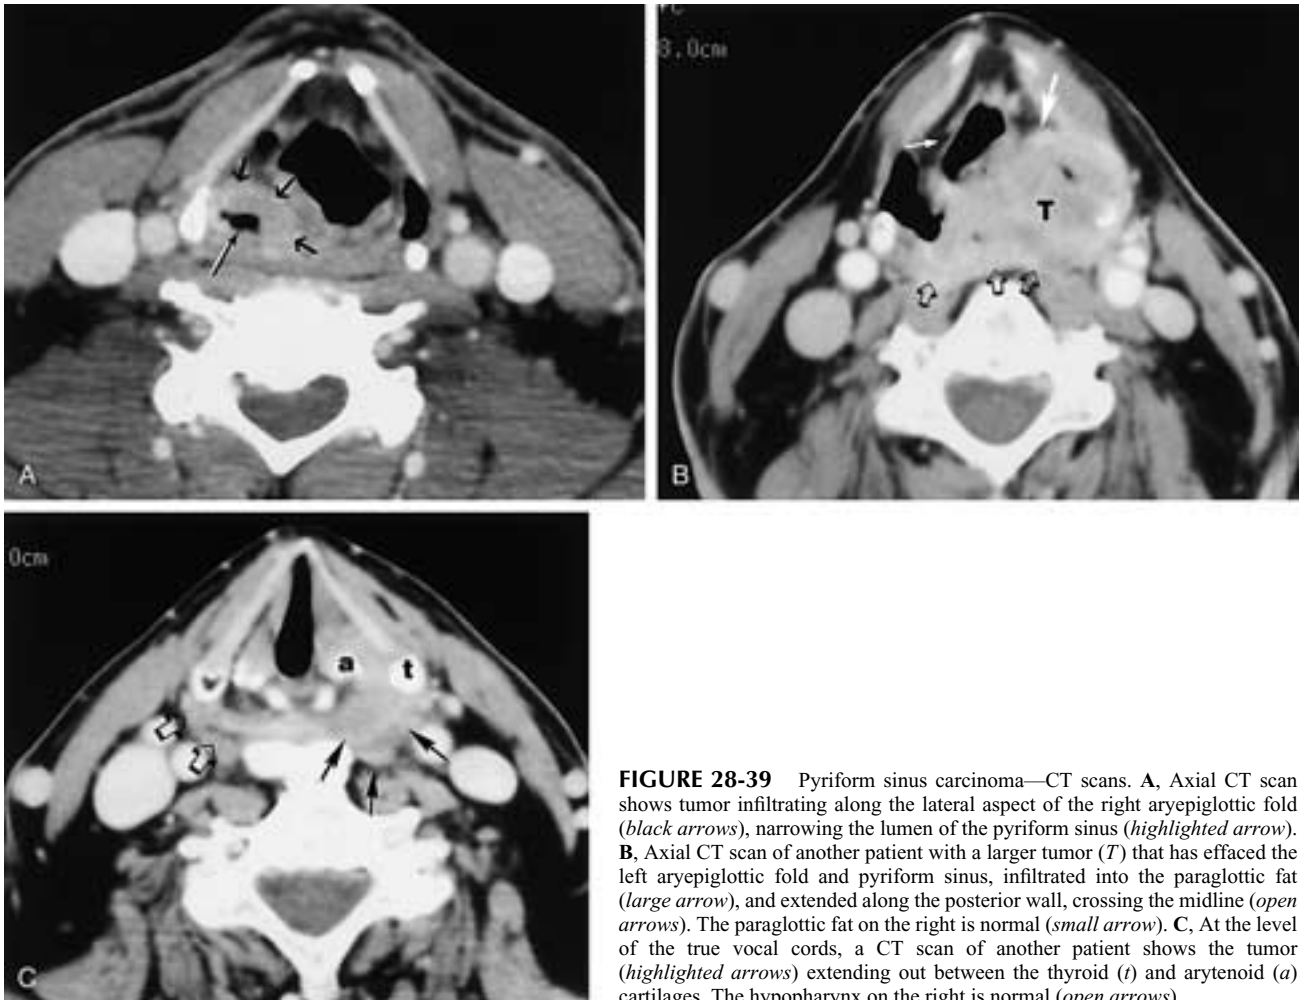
Pyriform sinus carcinoma—CT scans. A, Axial CT scan shows tumor infiltrating along the lateral aspect of the right aryepiglottic fold (*black arrows*), narrowing the lumen of the pyriform sinus (*highlighted arrow*). B, Axial CT scan of another patient with a larger tumor (*T*) that has effaced the left aryepiglottic fold and pyriform sinus, infiltrated into the paraglottic fat (*large arrow*), and extended along the posterior wall, crossing the midline (*open arrows*). The paraglottic fat on the right is normal (*small arrow*). C, At the level of the true vocal cords, a CT scan of another patient shows the tumor (*highlighted arrows*) extending out between the thyroid (*t*) and arytenoid (*a*) cartilages. The hypopharynx on the right is normal (*open arrows*).
